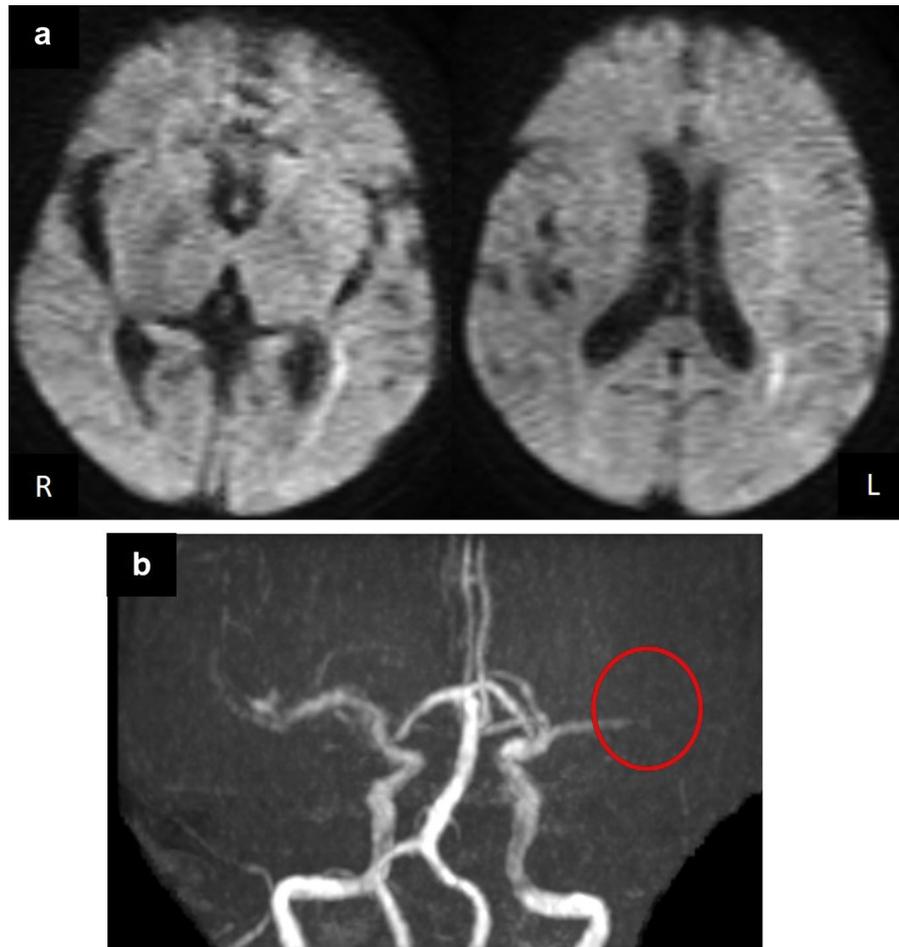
MRI/MRA study on the development of right hemiparesis and aphasia including a) MR-DWI showing DWI-ASPECTS of 8, meaning that almost all areas of left MCA were not infarcted but represented penumbra and b) MRA showing that left MCA was occluded at the red circled point. ASPECTS = Alberta Stroke Program Early Computed Tomography Scores; DWI = diffusion-weighted imaging; MCA = middle cerebral artery; MRA = magnetic resonance angiography; MRI = magnetic resonance imaging. (For interpretation of the references to color in this figure legend, the reader is Referred to the web version of this article.)
